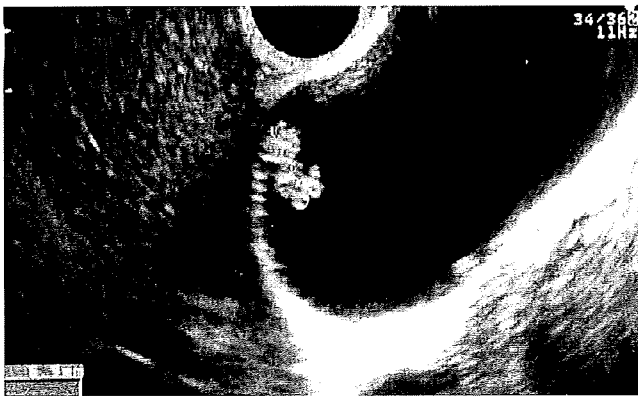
Ultrasound image of a cholesterol polyp: sessile polyp that has a higher echoic signal than the liver
